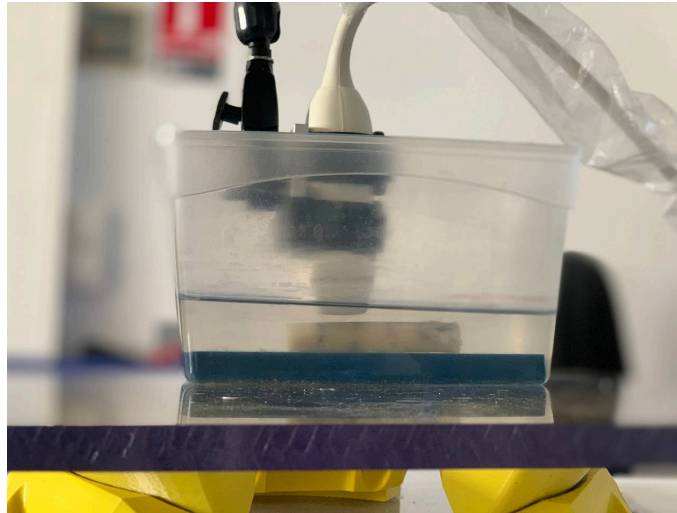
Experimental setup for ultrasound data acquisitions *ex vivo*, with the probe positioned in front of the sample, slightly submerged in water
